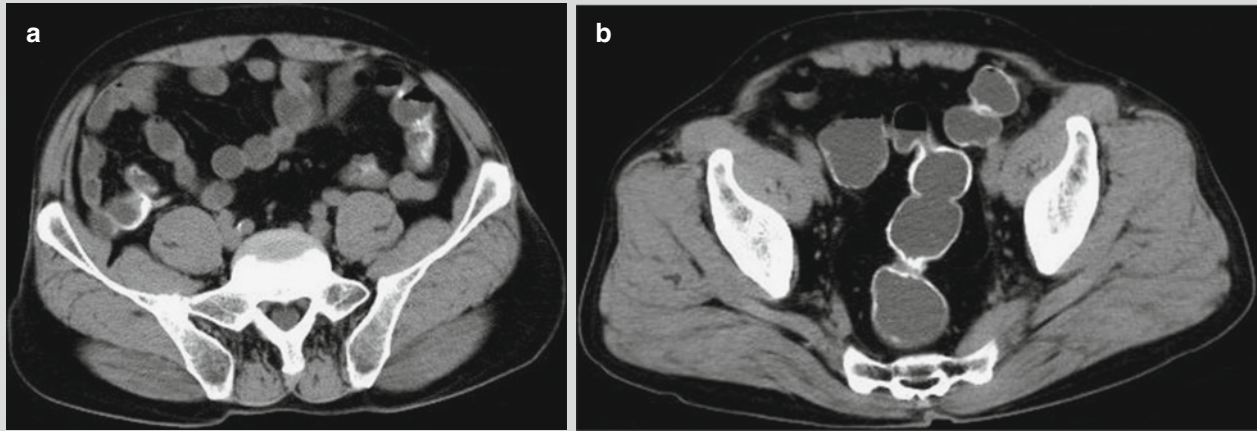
Intestinal schistosomiasis. (a) Plain CT scanning demonstrates calcification at the intestinal wall of ileocecal junction, appendix, and descending colon. (b) Calcification is demonstrated at the intestinal wall of rectum and sigmoid colon
